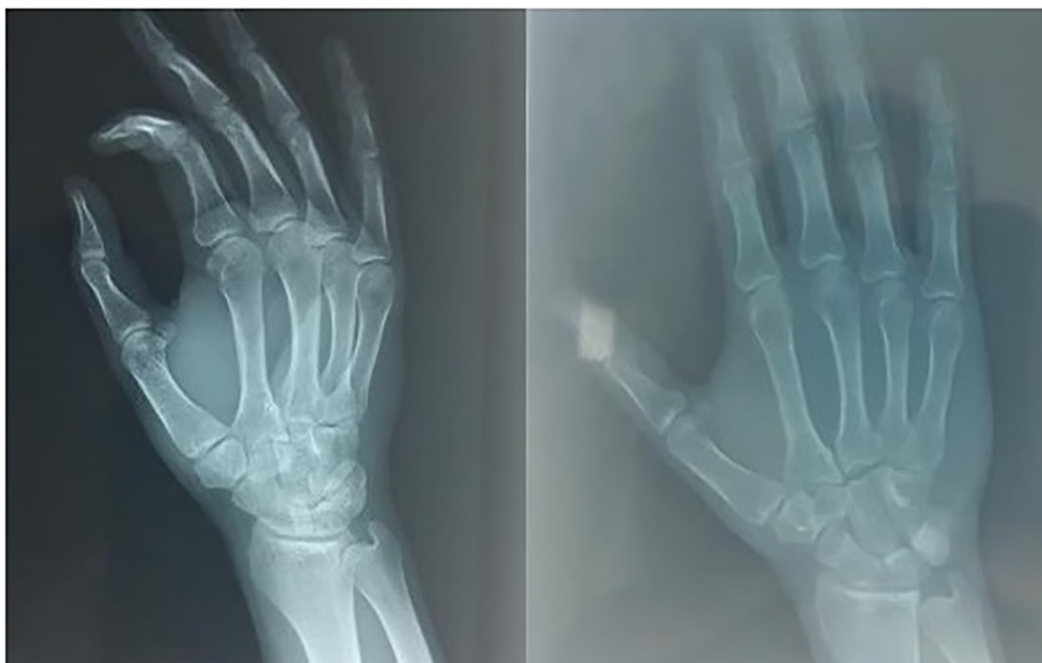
Hand X-rays after K wires removal.
